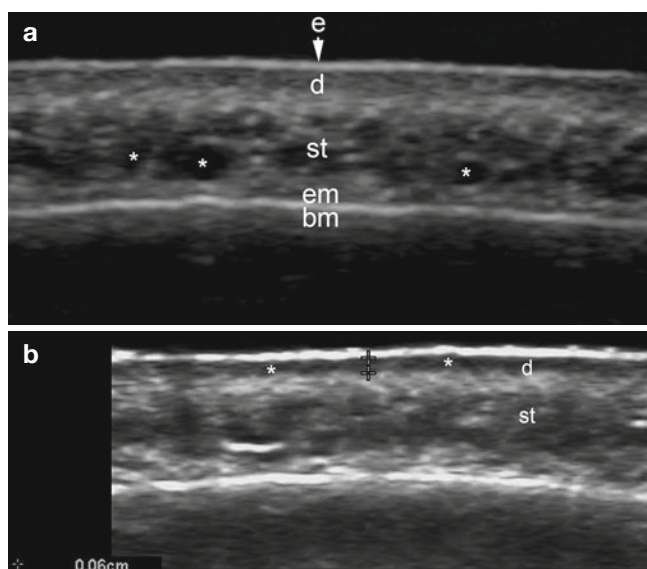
(a, b) Normal frontal skin. (a) Ultrasound (transverse view). Note prominent subcutaneous veins (*). (b) Note subepidermal low echogenicity band (*, between markers), a sonographic sign of photoaging. Abbreviations: *e* epidermis, *d* dermis, *st* subcutaneous tissue, *em* epicranial muscle, *bm* bony margin of the skull
